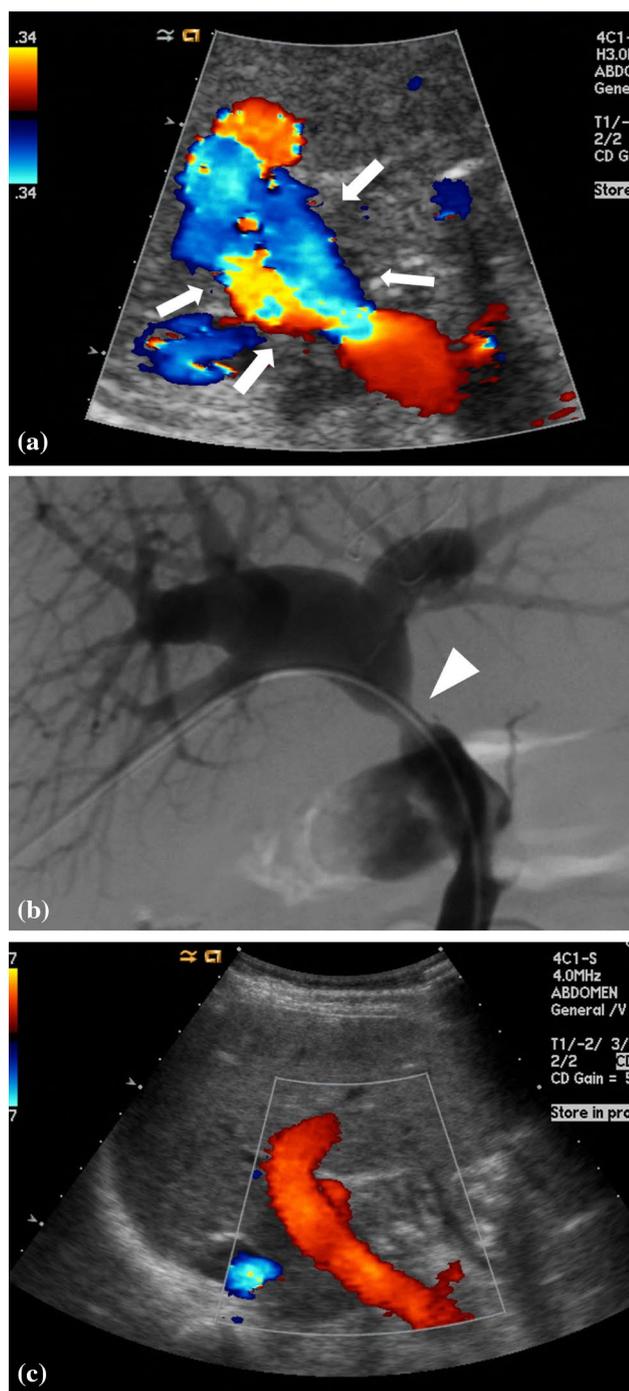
A 27-year-old female with portal vein stenosis after whole liver transplantation from cadaveric donor. a Color Doppler sonogram shows turbulent flow, with alternating bands of red and blue flows within the graft portal vein (arrows). b Portal venography shows tight anastomotic stenosis (arrowhead). c After treatment with portal vein stenting, follow-up color Doppler sonogram shows disappearance of turbulent flow at the graft portal vein
